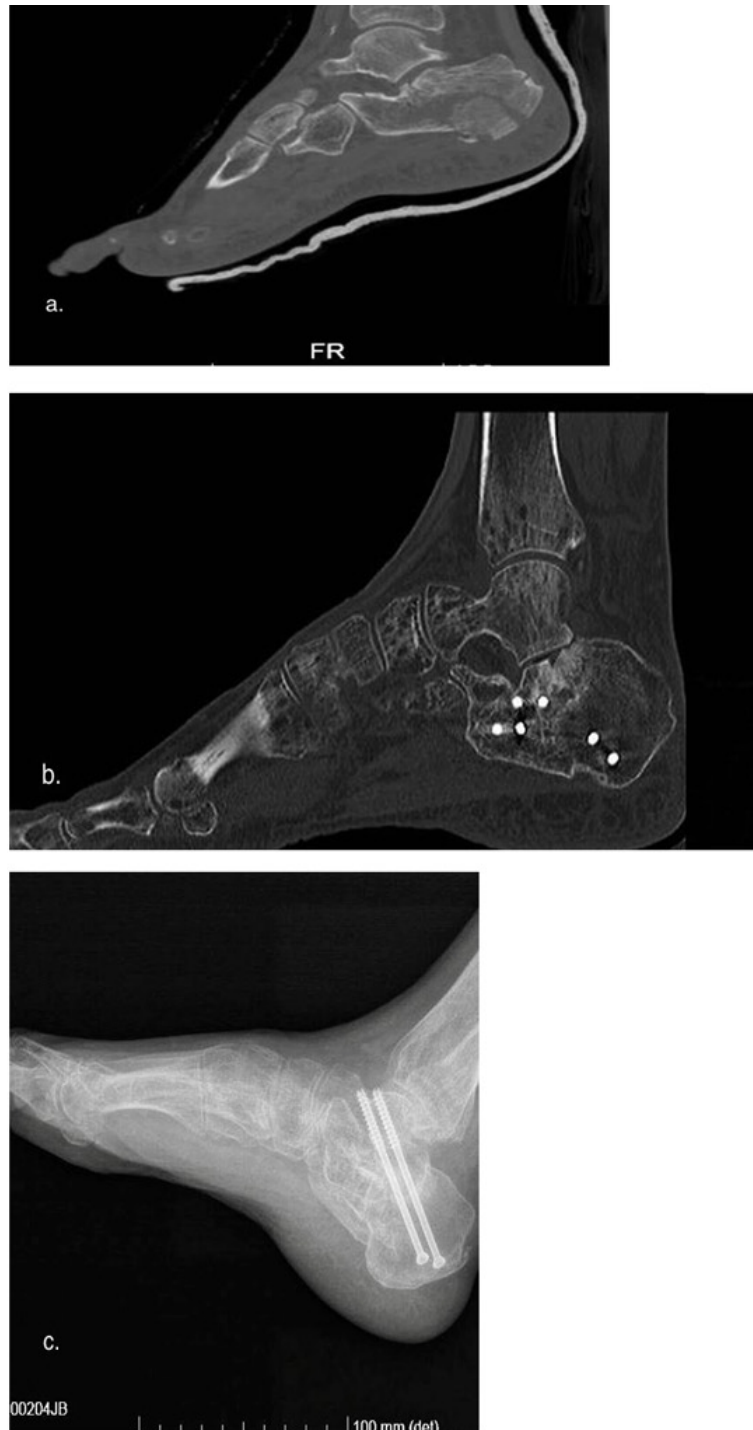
a, Preoperative CT scan, man 56 y, (b) CT scan after 30 months, (c) post-operative (secondary subtalar arthrodesis) X-ray.
